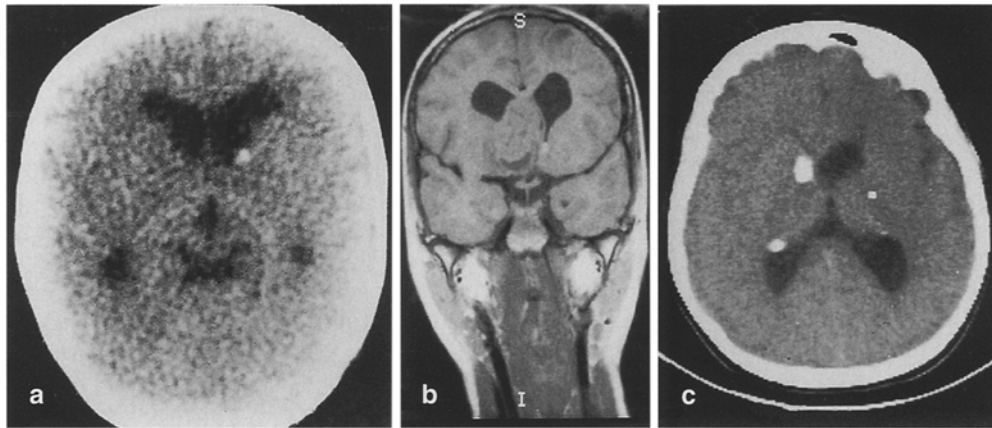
a CT scan at the age of 6 months. Minute intraventricular calcification was observed in the left anterior horn with marked ventricular dilatation. b Magnetic resonance (T1-weighted) image of the same patient at the age of 9 years, showing a large left frontal tumor with hydrocephalus. c Postoperative CT scan showing resected tumor in the left frontal horn. Two minute calcifications were seen in the trigones of both lateral ventricles and a large one in the right frontal horn. The ventricles have decreased in size
